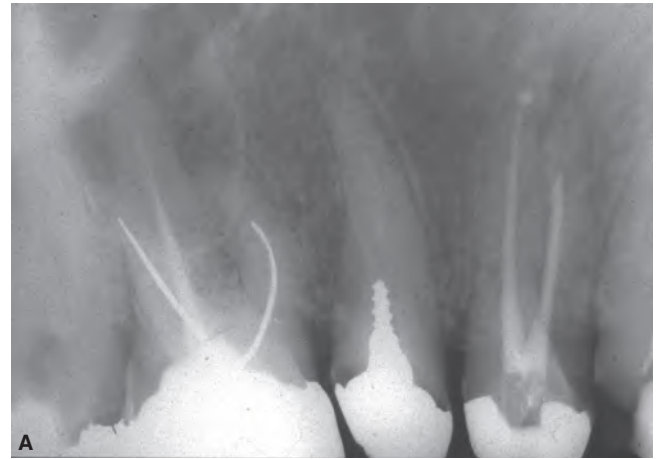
A. The maxillary second premolar is scheduled to be retreated before placement of a new restoration. Coronal and intracanal obstacles must be removed. B. The root canal is negotiated. C. Postoperative radiograph demonstrating obturating material in a lateral canal and apical ramifications.
